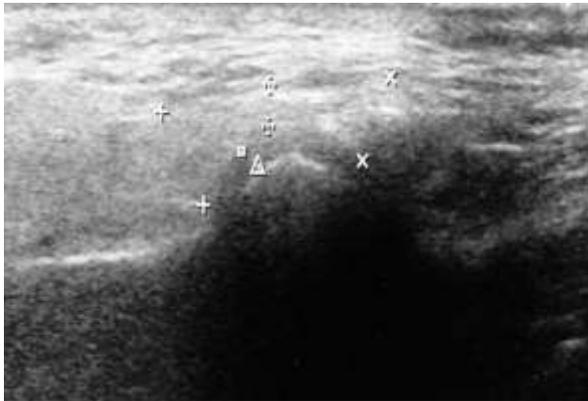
Ultrasound Image of the Articular Disc Before Treatment; the Boundaries of the Disc are Indicated by Dots
